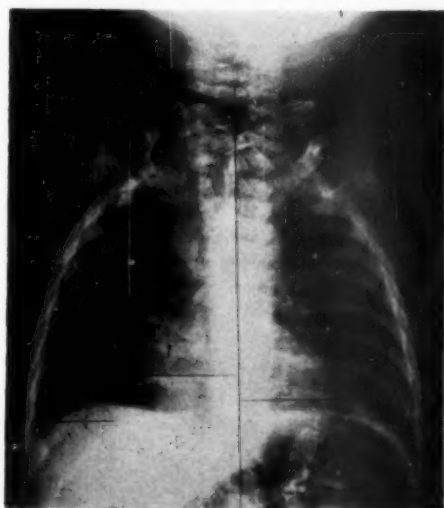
Posteroanterior roentgenogram of chest.
